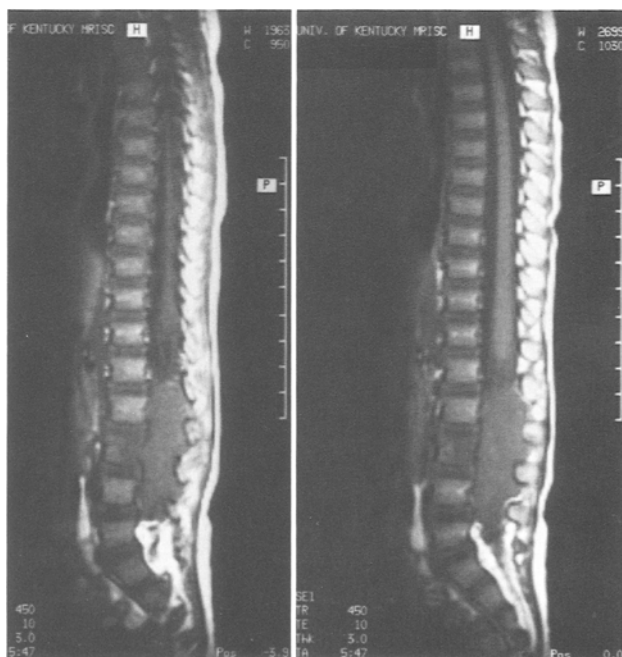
The T1-weighted sagittal MR image of the spine showed a large extradural mass located below the conus, extending from L1 to L5, compressing the cauda equina and obliterating the sacrum (case 1)
